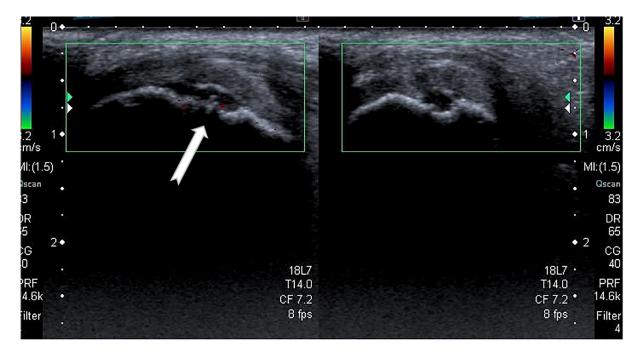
Subtle increased hyperemia (neovascularity) with Power Doppler imaging of the right knee (left image of split screen in comparison to asymptomatic left knee).
